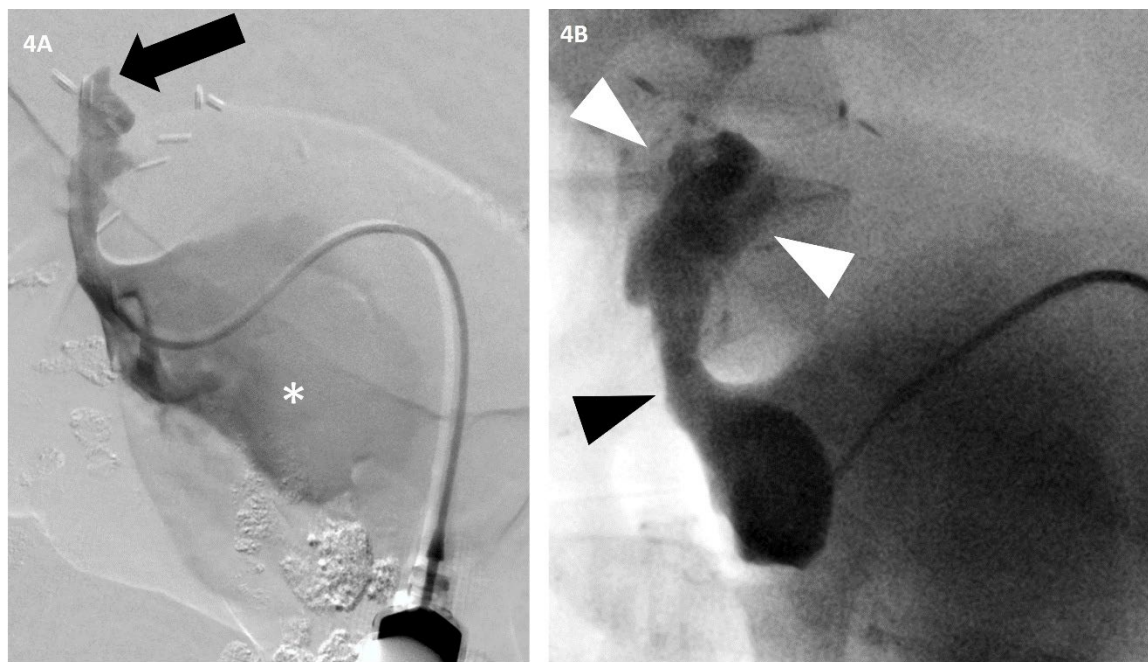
(A) Digital subtraction radiography showing a catheter placed in the lymphocele (black arrow) through the lymphopseudoaneurysm (asterisk). (B) Fluoroscopic image showing the presence of NBCA-glue mixture with Lipiodol in the LPA (white arrowheads) and in its connection with the lymphocele (black arrowheads).
